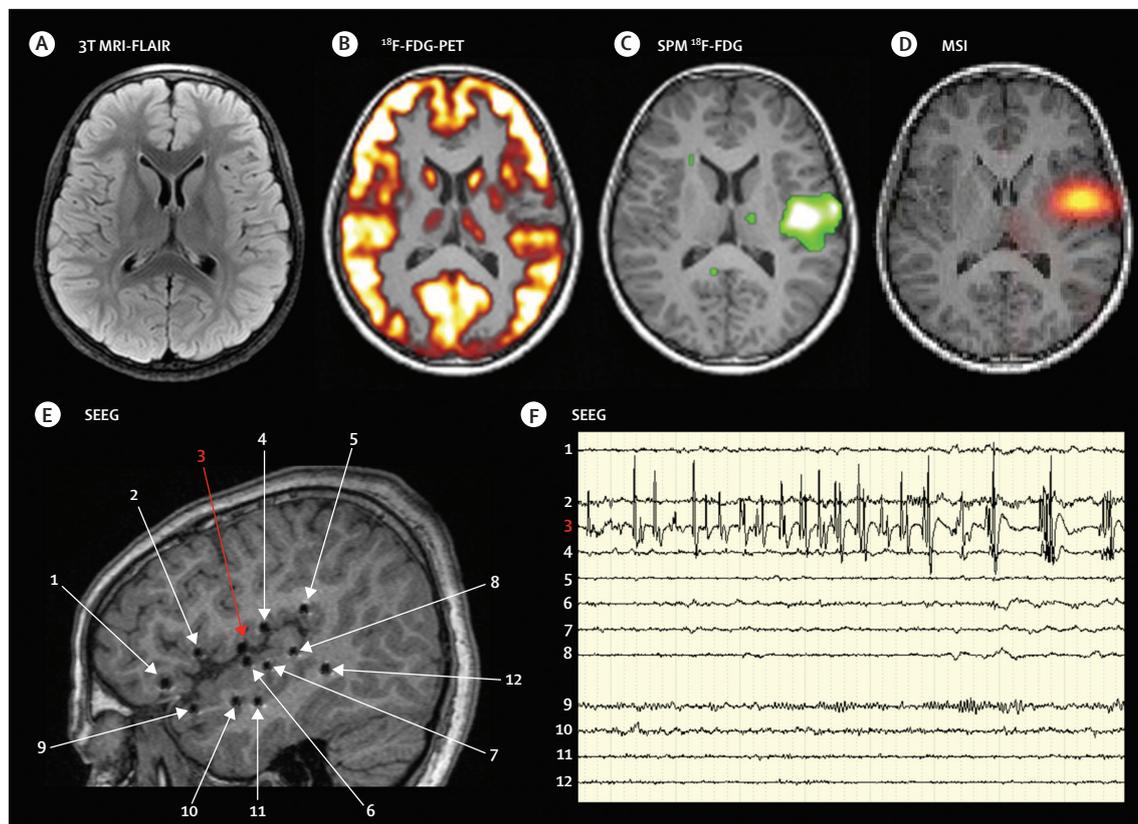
Presurgical investigations in a patient with refractory epilepsy symptomatic of an MRI-occult type 2 focal cortical dysplasia in the frontal operculum on the side dominant for language.
